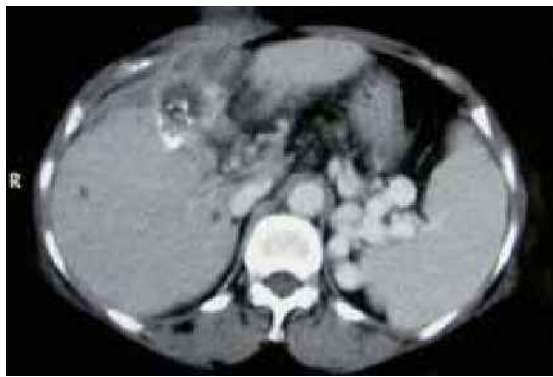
Axial CT image shows tumour implantation along previous needle biopsy tract, extending from the primary tumour to the skin.
